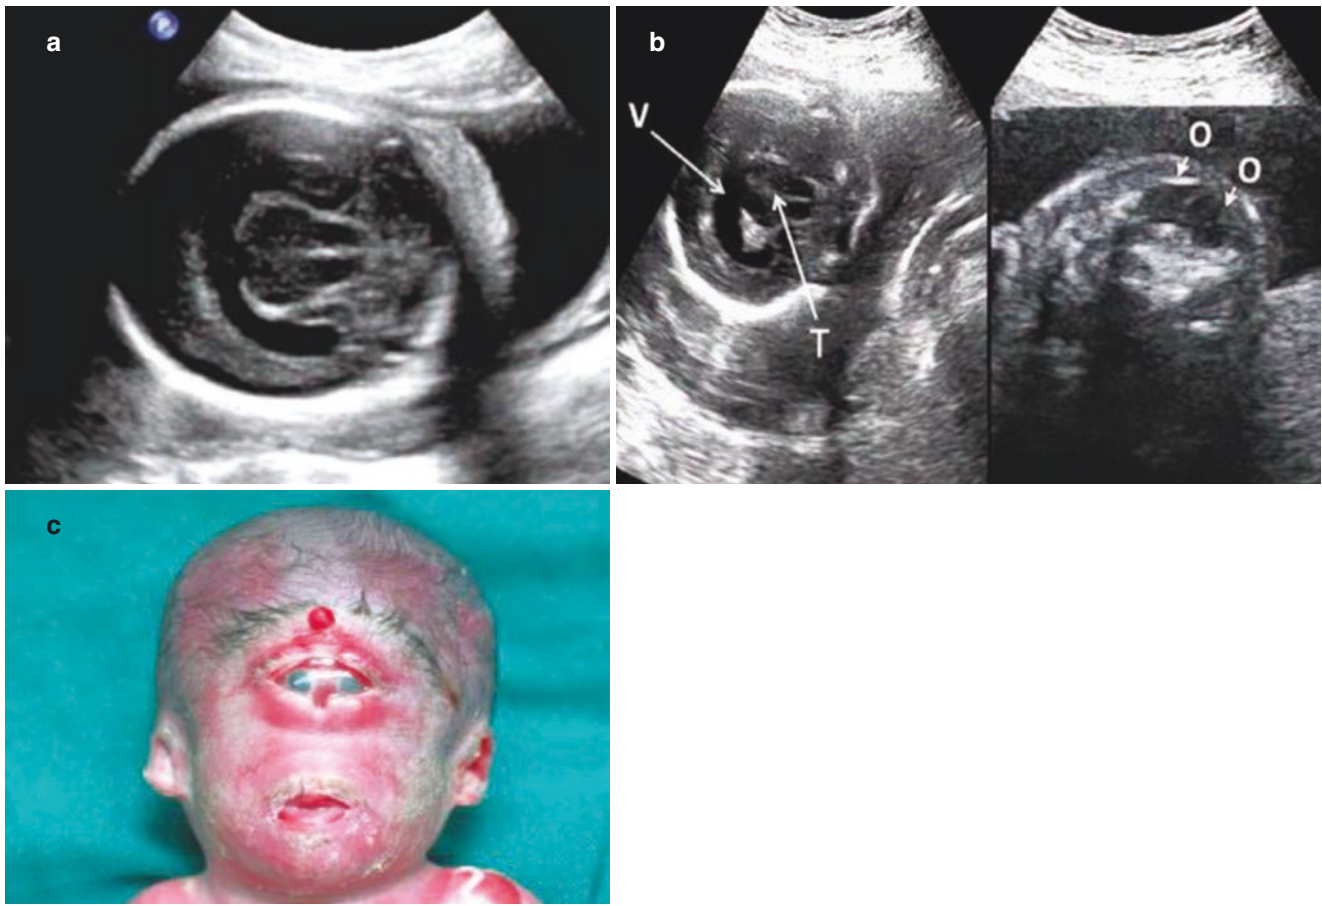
Holoprosencephaly. (a). Typical ultrasonic imaging. (b, c). Combined hypotelorism
